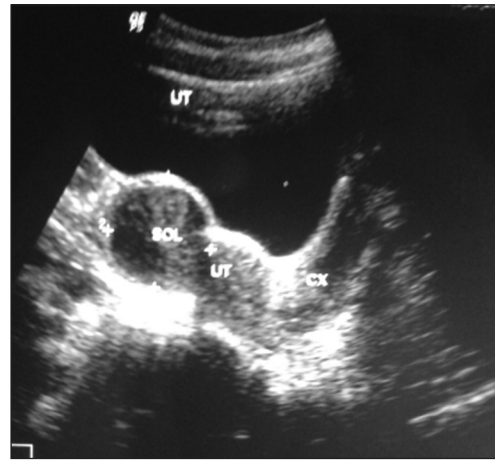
Ultrasound showing fibroid uterus
